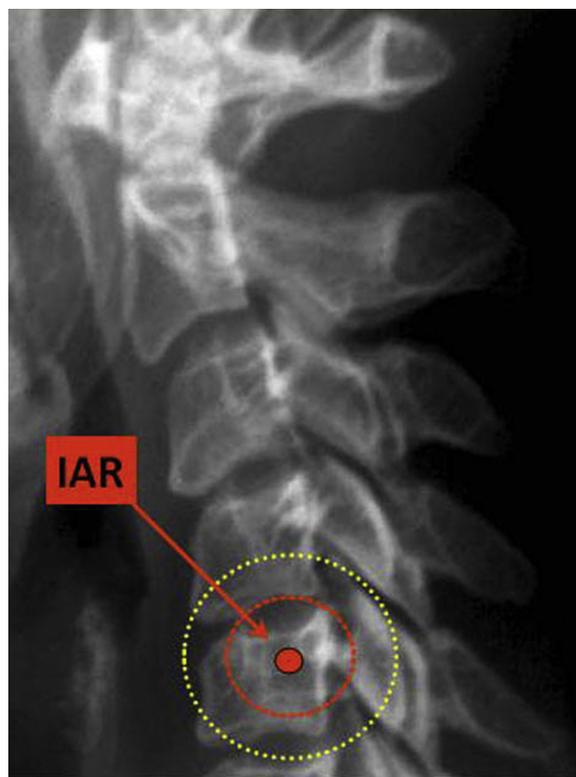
Lateral radiograph of the cervical spine in flexion. During flexion–extension the vertebra moves around a transverse rotation axis placed in the subjacent vertebral body. Both the endplates and the facet joints perform two circumference arcs around the same rotation centre.
